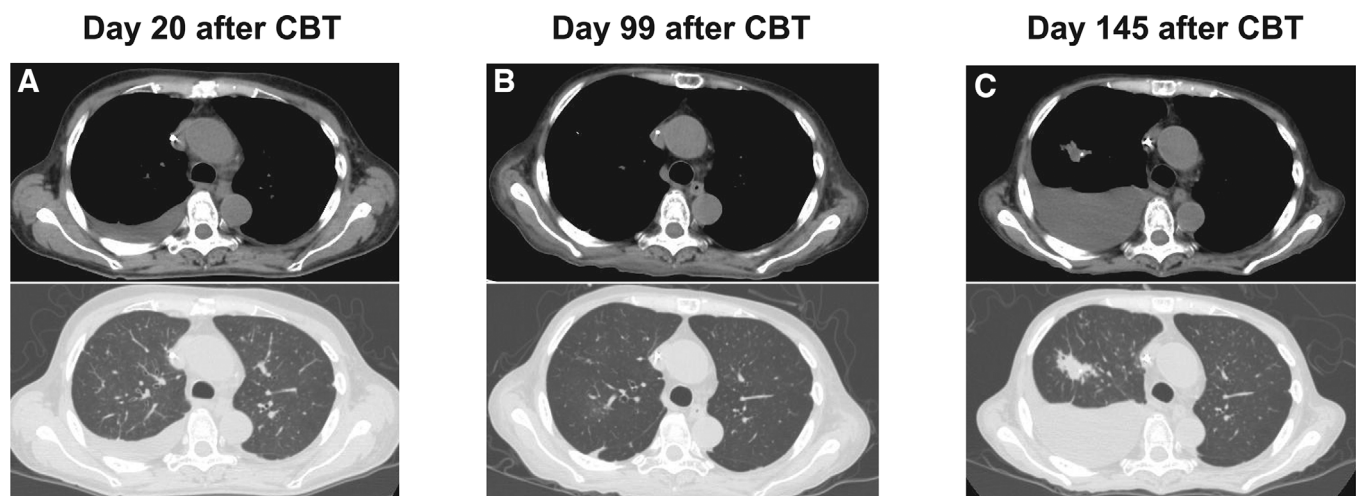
Unenhanced computed tomography scan showing right pleural effusion on day 20 (A), day 99 (B), and day 145 (C) after CBT. Upper: mediastinal condition, lower: lung field condition
